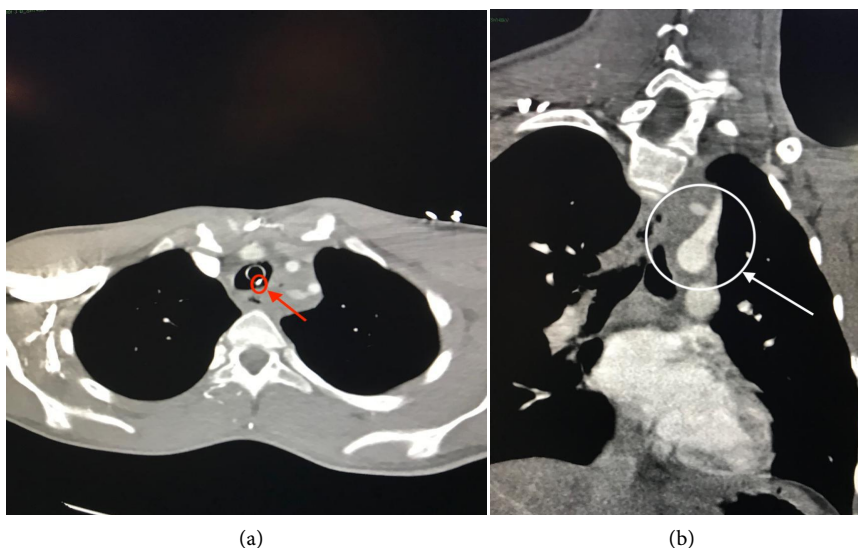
(a) CT scan showing the clip inserted initially to control the bleeding (arrow); (b) Sagittal view computed tomography of chest showed pseudo-aneurysmal changes at left subclavian artery with leaked contrast through the fistula toward the esophagus (arrow).
